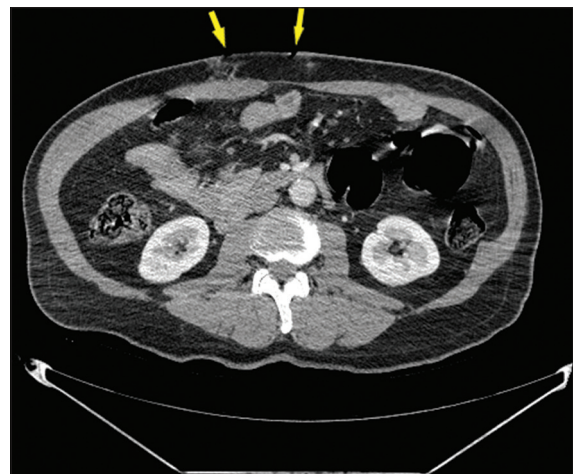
The yellow arrows show stab wound entrances on the axial plane of the CT scan. CT: Computed tomography
